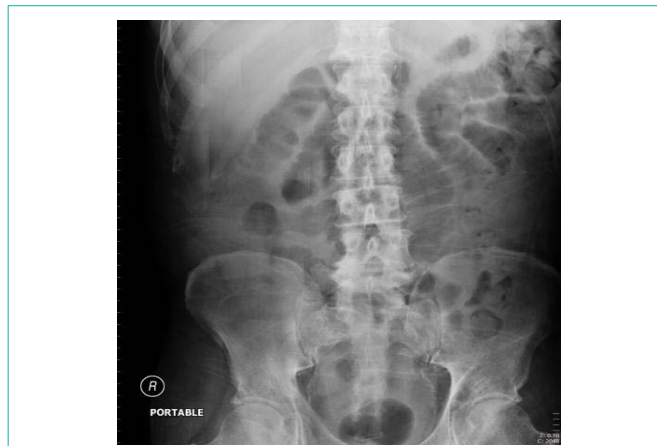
Portable AP x-ray view of the abdomen.
